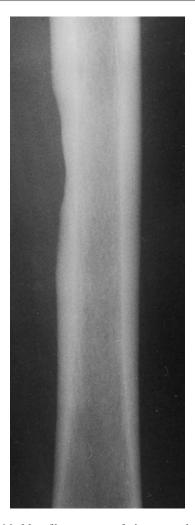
Myxofibrosarcoma of the upper leg in a 65-year-old man. Plain radiograph. Soft tissue mass causing pressure erosion on the medial cortex of the femoral diaphysis
